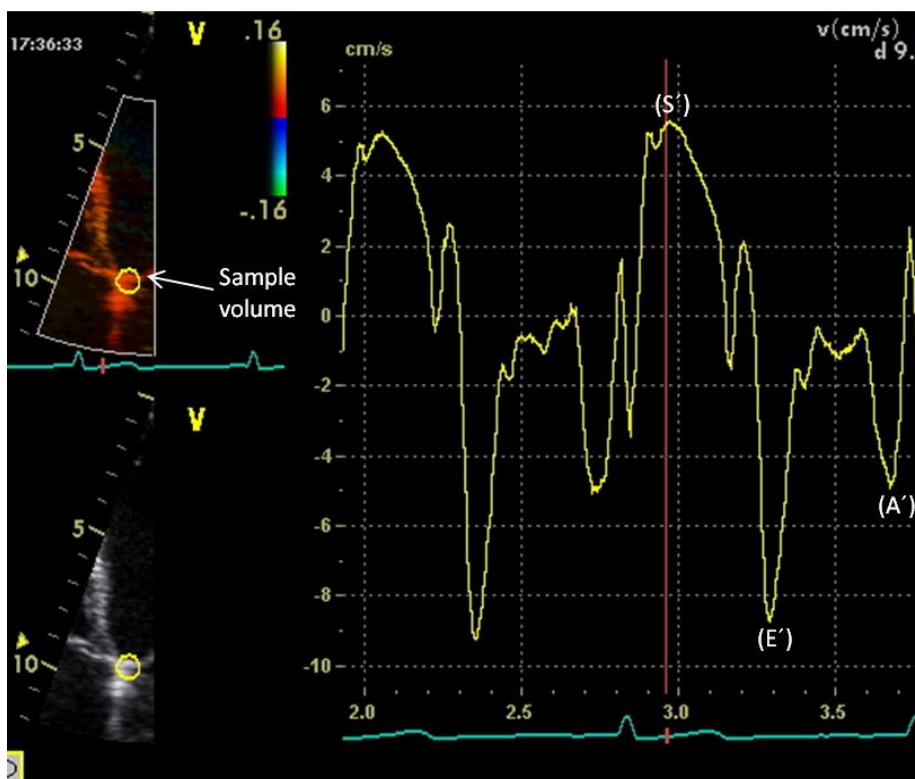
Example of an apical 4-chamber view, reduced to show the intraventricular septum and mitral annulus only.
